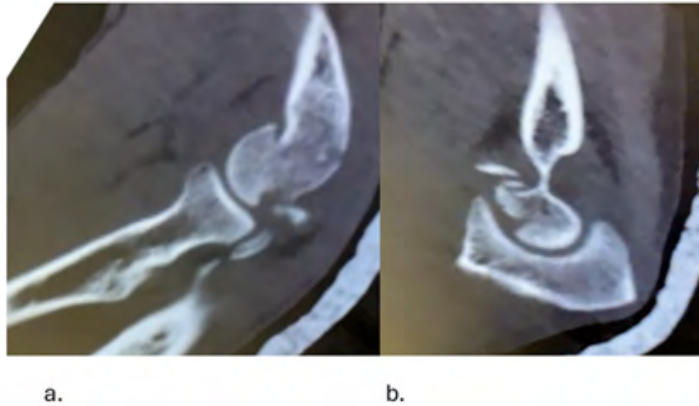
CT of the left elbow of the 2nd patient. a. The cut demonstrates the posterior lesion in the capitellum laterally. b. more medial cut shows the trochlear fracture.
